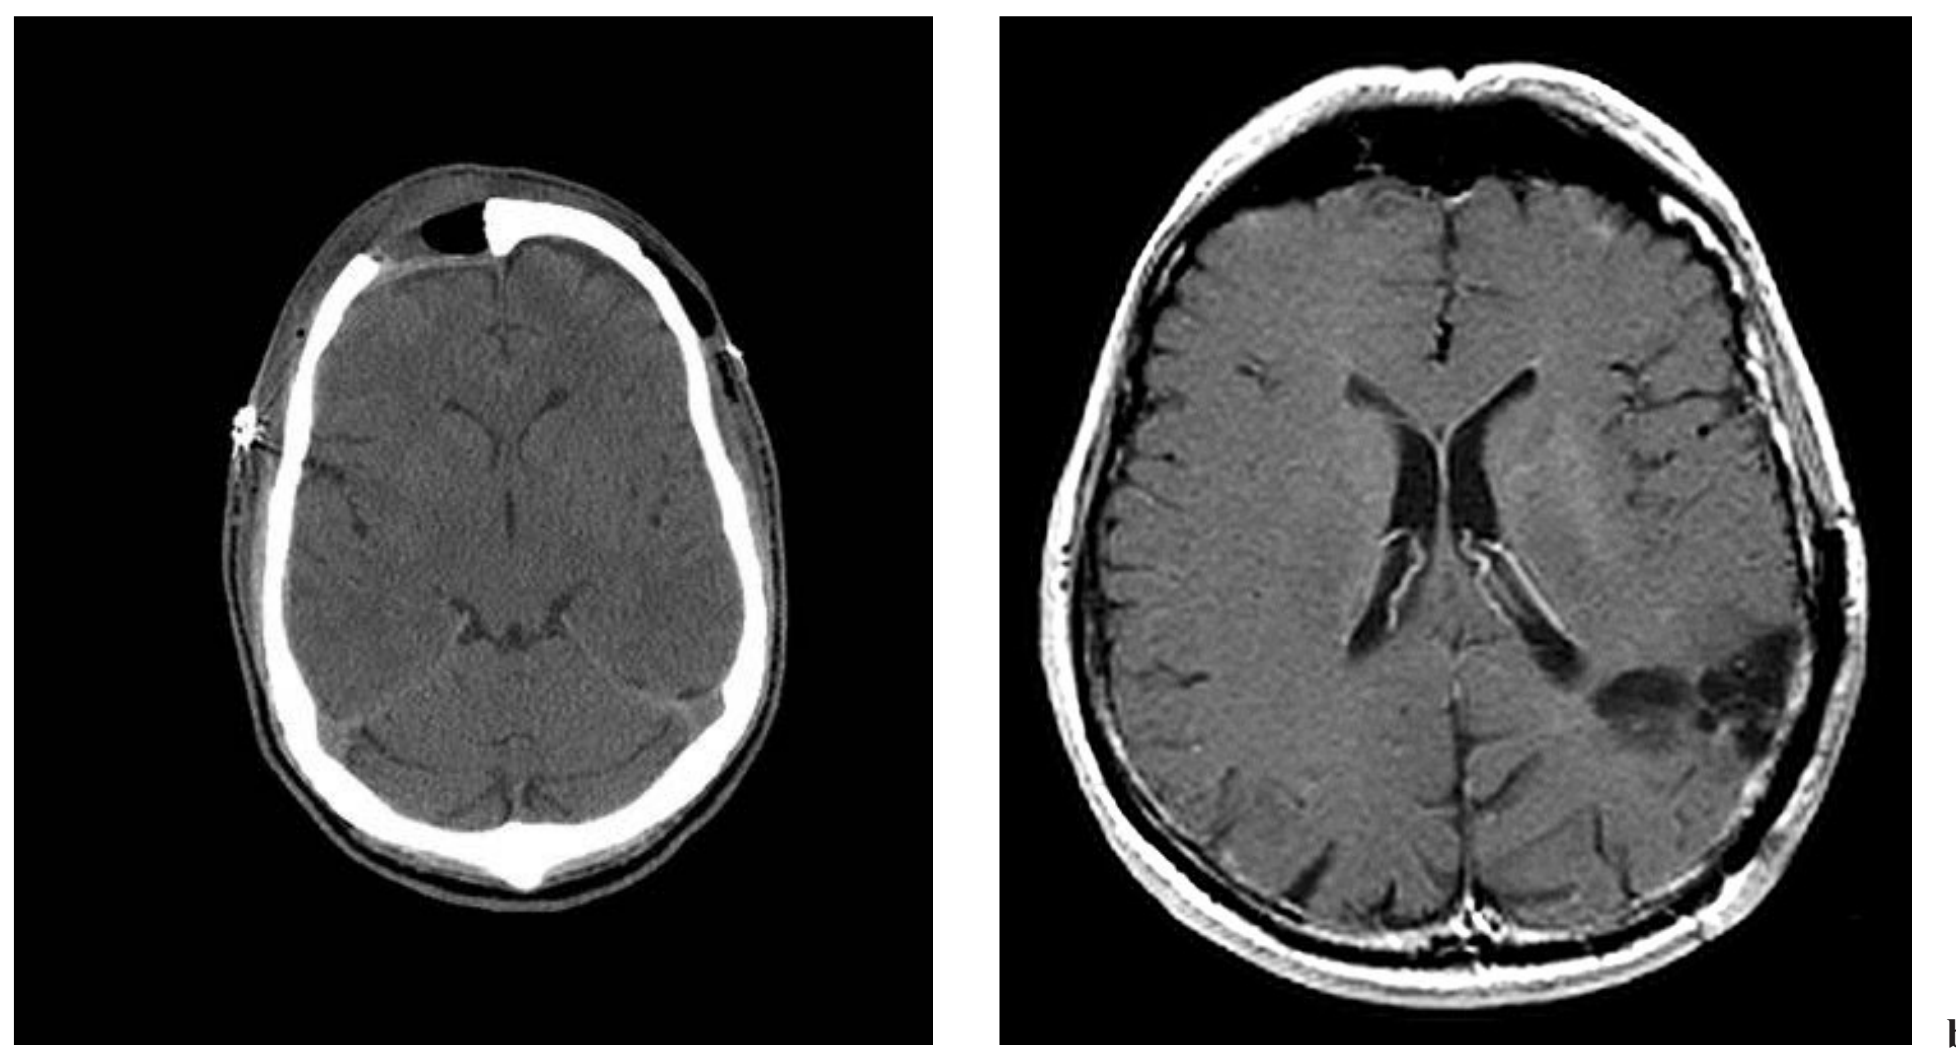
b (a) Non-contrast CT scan demonstrating local craniectomy and debridement of epidural abscess for the patient depicted in Fig. 20.1a–c. (b) Post-gadolinium T1-weighted axial image demonstrating resolution of intracerebral abscess and associated meningeal enhancement for the patient depicted in Fig. 20.1f.
